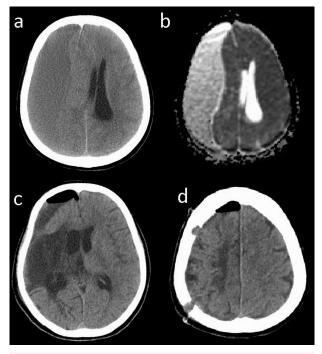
Right frontoparietal large subacute subdural hematoma and midline shift (a). In diffusion-weighted examination, septation within the hematoma and no parenchymal infaction are observed (b). On the CT examination of the 3rd postoperative day, a wide right temporal and partial infarction is observed in the right frontoparietal area
